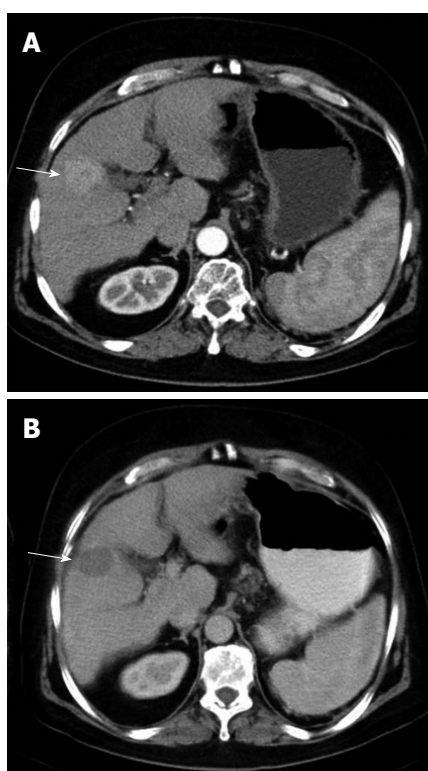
Axial computed tomography images before and after radiofrequency ablation shows an arterial enhancing lesion (arrow, A). That is replaced by a hypodense area without any enhancement following radiofrequency ablation (arrow, B).
